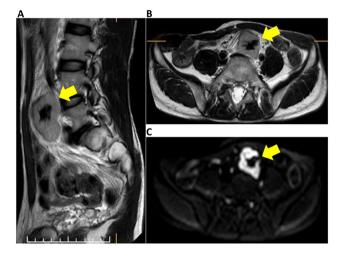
Pelvic MRI findings. (A) MRI sagittal T2; the arrow shows the 50 mm solid mass with high intensity. (B) MRI axial T2; the arrow points to the high intensity mass with a low intensity lesion. (C) MRI axial diffusion weighted image. The arrow points the mass with high intensity. MRI, magnetic resonance imaging.
